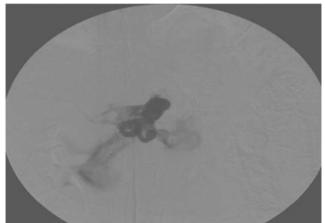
58-year-old woman with abondan GI bleeding because of the spontan splenic artery rupture in the CT image(a). Conventional angiography shows splenic aneurysm and extravazation (b).
